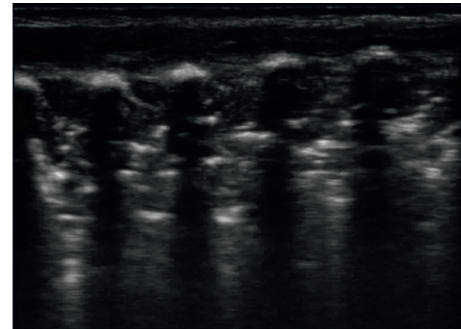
The lung B-ultrasound image of one subject in the experimental group. Note: the line A disappeared and the pleural line was abnormal.
